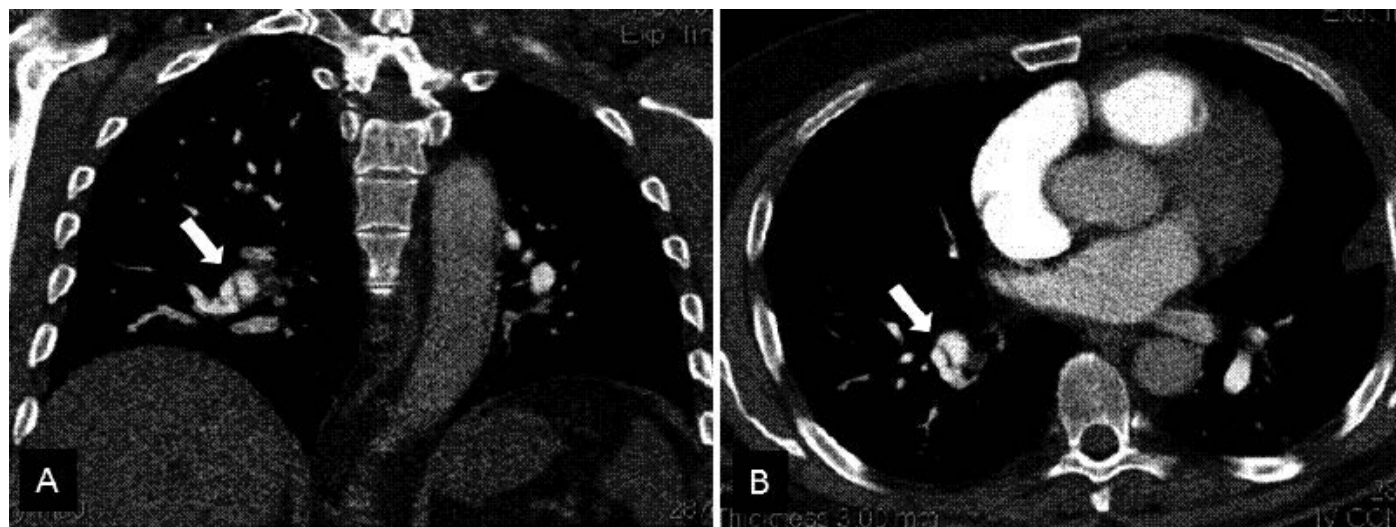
Computed tomography angiography chest with intravascular linear webs characteristic of chronic thromboembolic pulmonary hypertension (arrow). (A) Coronal plane. (B) Axial plane.
